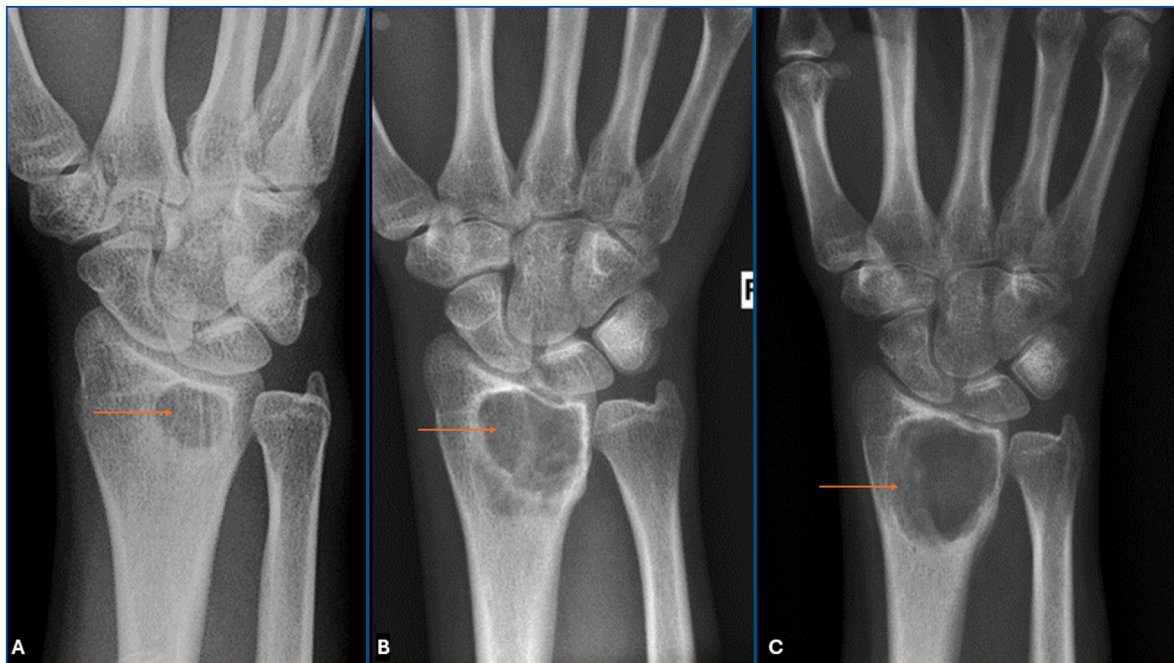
A–C: Progressive increase in both size and subarticular extension in this distal radius GCTB through serial imaging from (A) initial diagnostic radiograph, (B) through pregnancy and finally (C) postpartum. Radiographic progression corresponded with symptom deterioration through this period.
